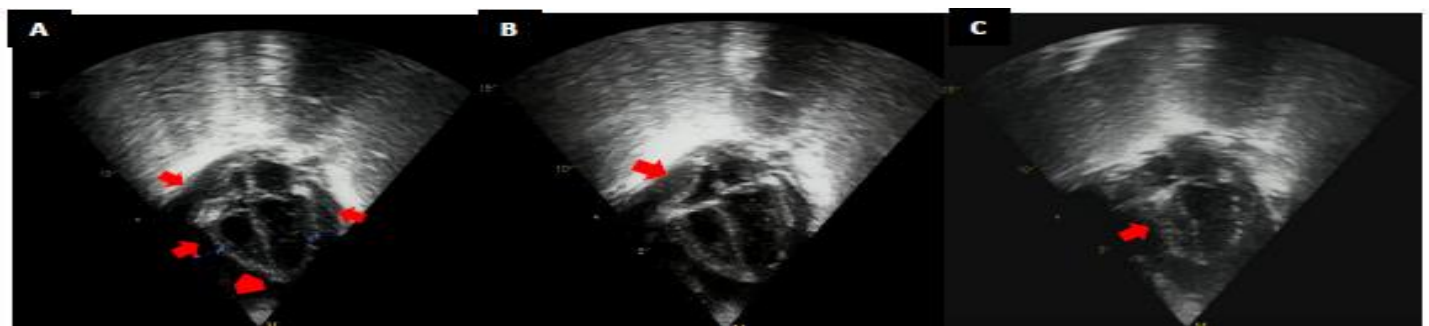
Four chamber view of the patient’s echocardiography and tamponade physiology. A. Moderate circumferential pericardial effusion (Red arrows). Left ventricle side: 1.52 cm, Right ventricle side: 1.1 cm, Right atrial side: 1 cm. The red arrow in B is pointed to a collapse right atrium, while the arrow in C is focused on a collapse right ventricle.
